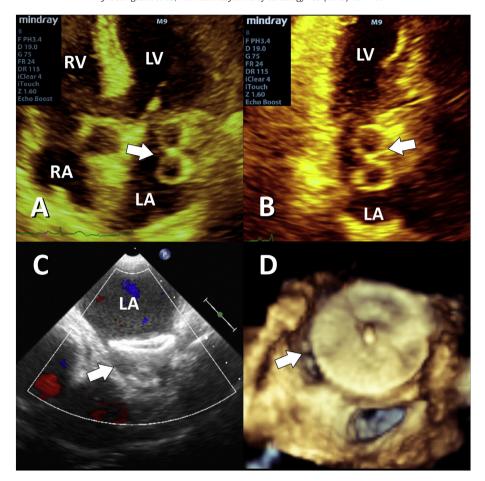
Panel A: Two-dimensional transthoracic echocardiography using the five-chamber view showing an image with the shape of the number eight in the left atrium (arrow). Panel B: Two-dimensional transthoracic echocardiography using the three chamber view showing the figure-of-eight artifact in the left atrium (arrow). Panel C: Two-dimensional Color Doppler transesophageal echocardiography demonstrating adequate ACP device positioning in the LAA (arrow). Panel D: Live three-dimensional echocardiography with en face visualization of the ACP device from the left atrium showing adequate ACP device positioning (arrow). LA indicates left atrium; LV, left ventricle; RA, right atrium; and RV, right ventricle.
